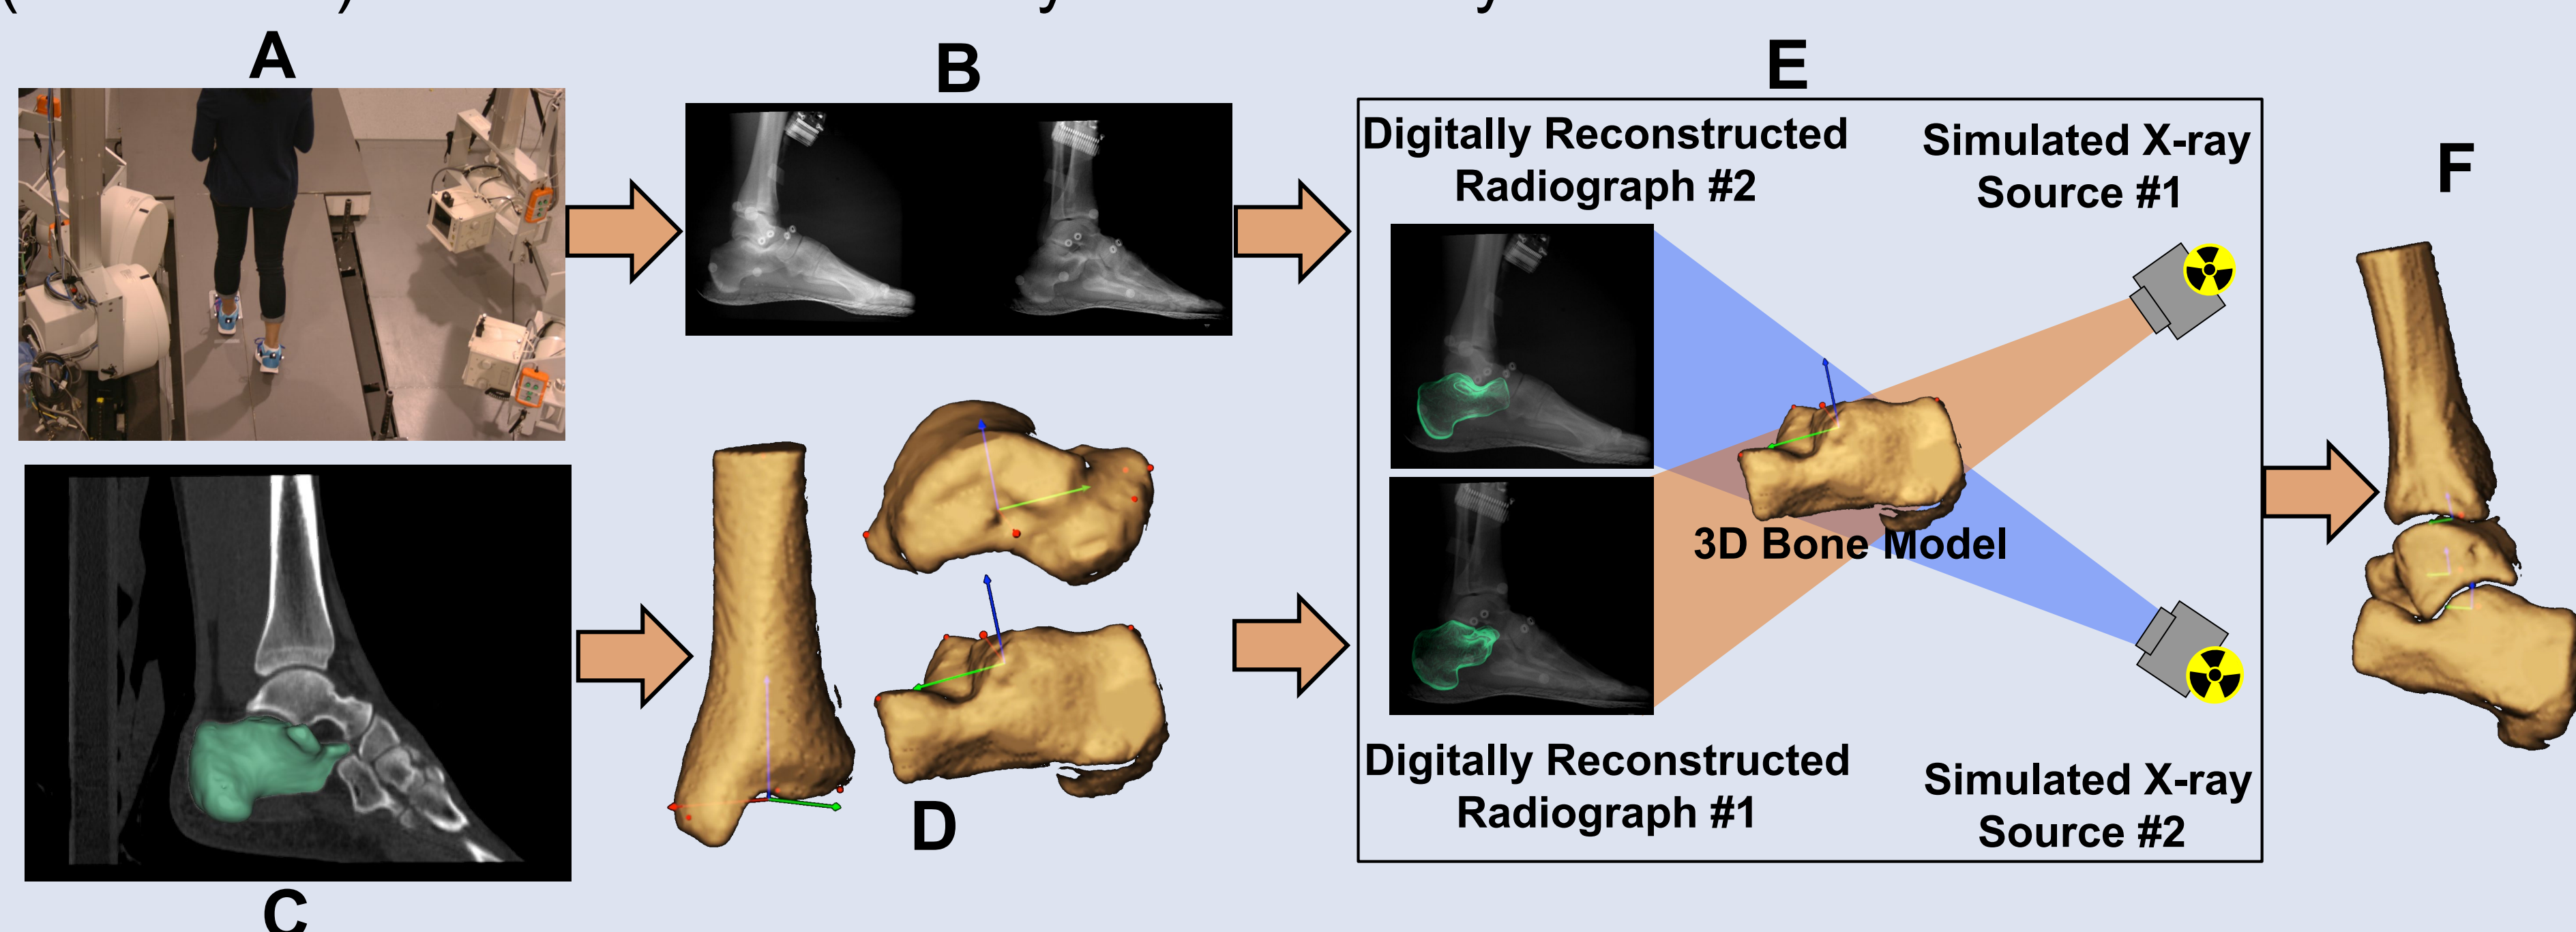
(A) Participants performed movement trials within the biplane radiography system. (B) Synchronized radiographs were collected at 100 and 150 images per second, with 1 ms exposure. (C) A CT scan (0.5 x 0.5 x 1.25 mm) of the ankle was segmented. (D) Anatomic coordinate systems were created⁹. (E) 3D knee kinematics were measured using CT MBT tracking process. (F) Calculated six degree-of-freedom kinematics of TT, ST and TF joints.
